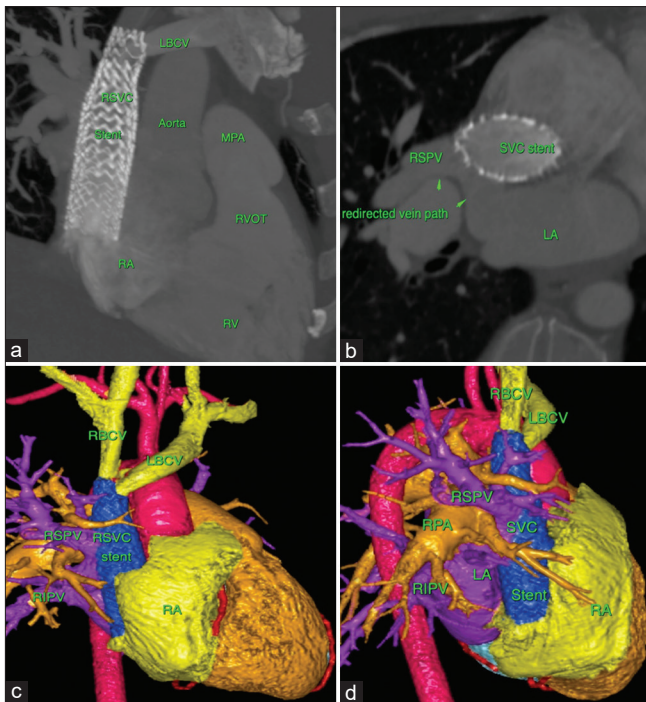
Computed tomographic reconstructed image 3 months after the procedure in modified sagittal (a) and modified axial (b) plane shows unobstructed drainage of left brachiocephalic vein to the right superior vena cava and finally to the right atrium, right ventricle, right ventricle outflow and main pulmonary artery (MPA) through the stent. The right superior pulmonary vein is redirected behind the covered stent to the left atrium. Volume-rendered images from the right anterior (c) and right lateral (d) views show a three-dimensional anatomy following the intervention. LBCV: Left brachiocephalic vein, RSVC: Right superior vena cava, RSPV: Right superior pulmonary vein, RV: Right ventricle, LA: Left atrium, RA: Right atrium, SVC: Superior vena cava, RBCV: Right brachiocephalic vein, RIPV: Right inferior pulmonary vein, RPA: Right pulmonary artery, RVOT: Right ventricle outflow, MPA: Main pulmonary artery
